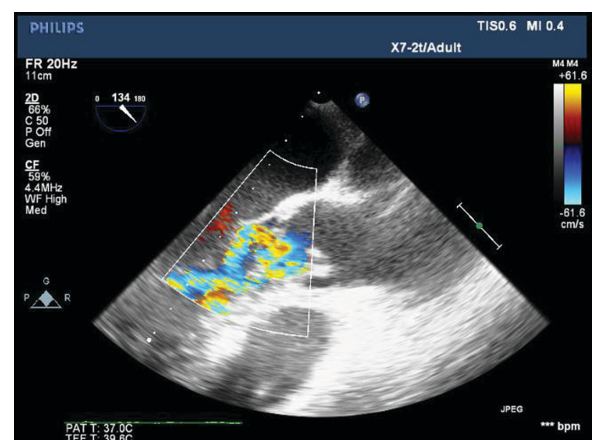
Intraoperative echocardiogram at 134 degrees showing the ruptured non-coronary cusp with color flow showing a significant aortic regurgitant jet.
